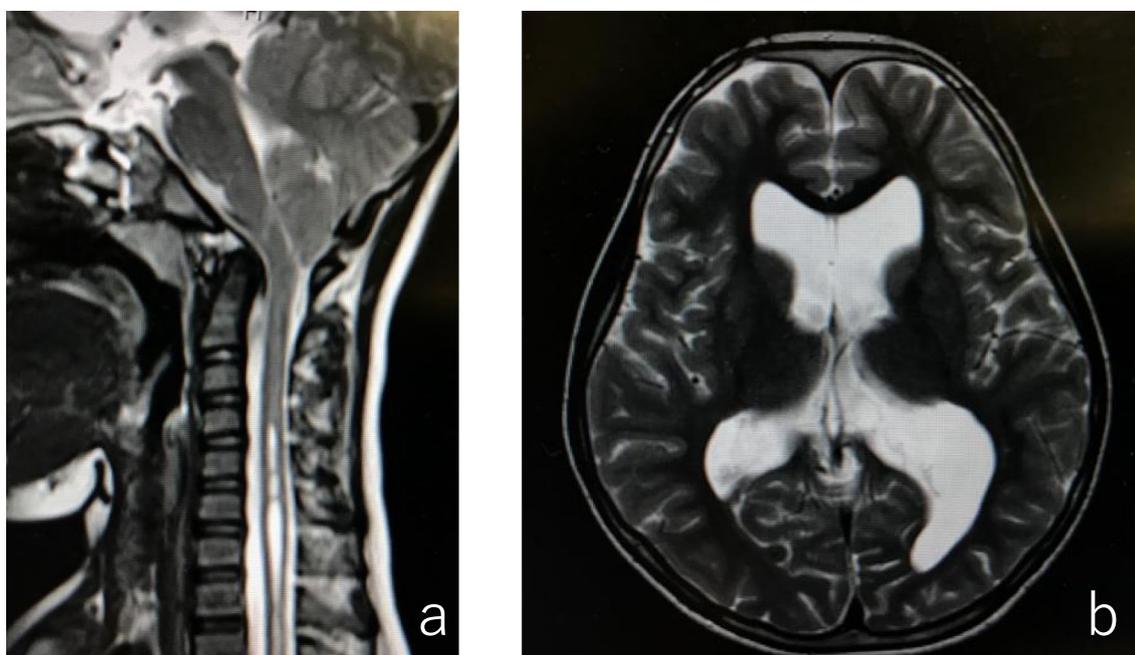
a Chiari type 1 malformation associated with syringomyelia. b Hydrocephalus was also recognized by MR images of the brain
